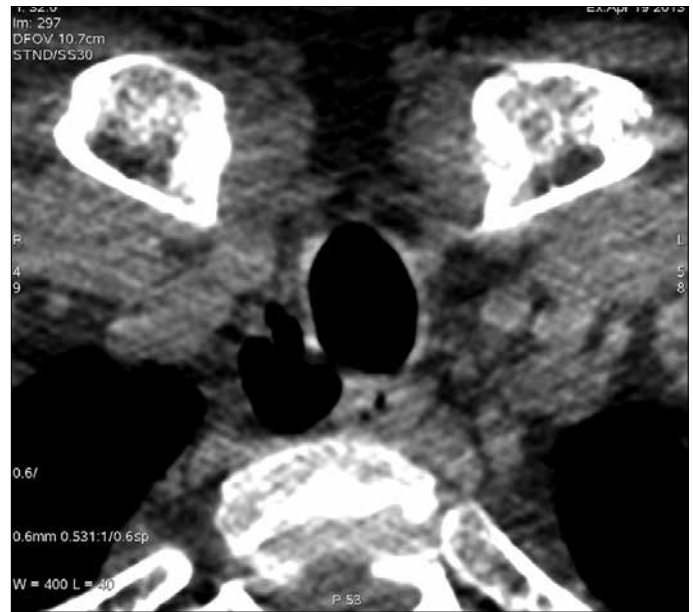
On CT axial section, right paratracheal diverticulum and its neck from oblique aspect
